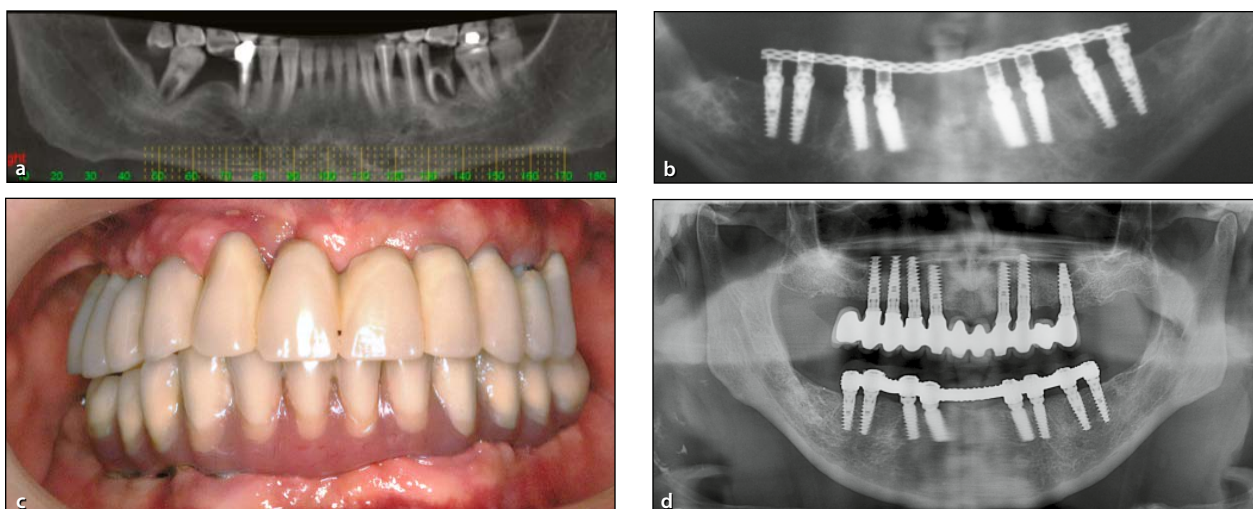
A representative case that was restored using the novel tissue-level angled-head dental implant system (mandible). (a) Preoperative radiographic view of the mandible. (b) Radiographic view immediately after placement of the implants and immediate restoration. (c) Clinical view of the final restoration. (d) Ten-year follow-up radiograph showing stable bone levels around the implants.
